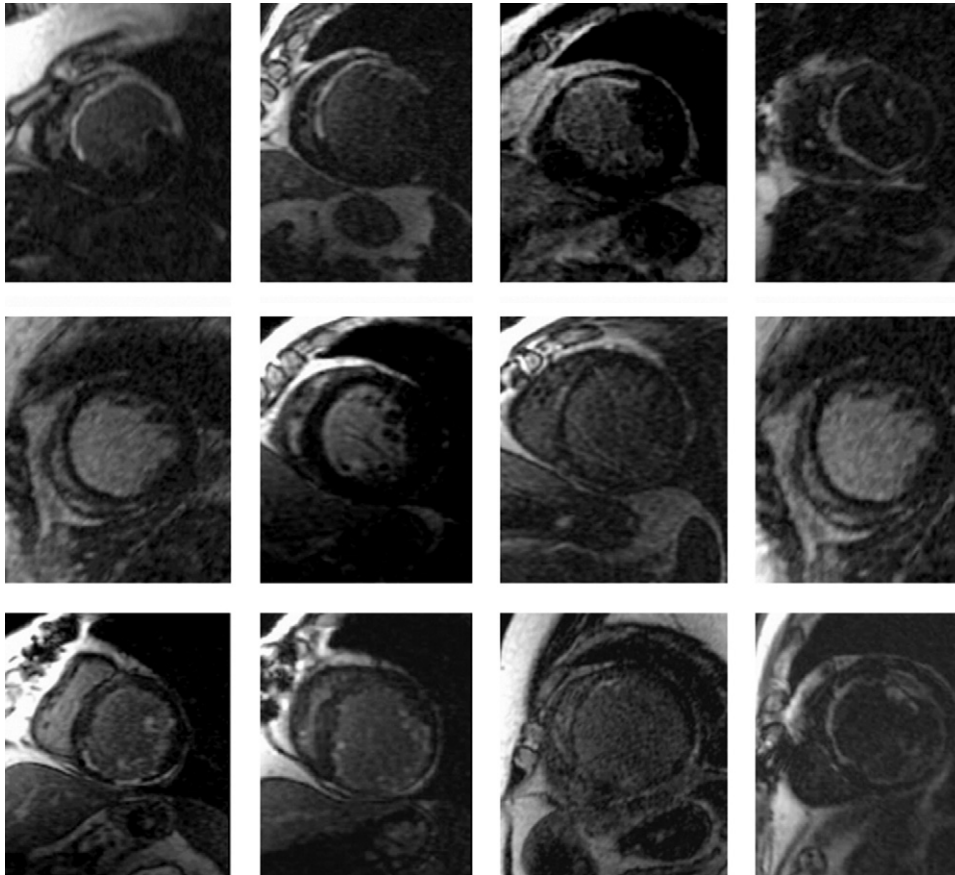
Examples of scar distribution (bright signal) on delayed-enhancement magnetic resonance imaging from clinical nonresponders (top row), responders without scar (middle row), and responders with scar (bottom row).
